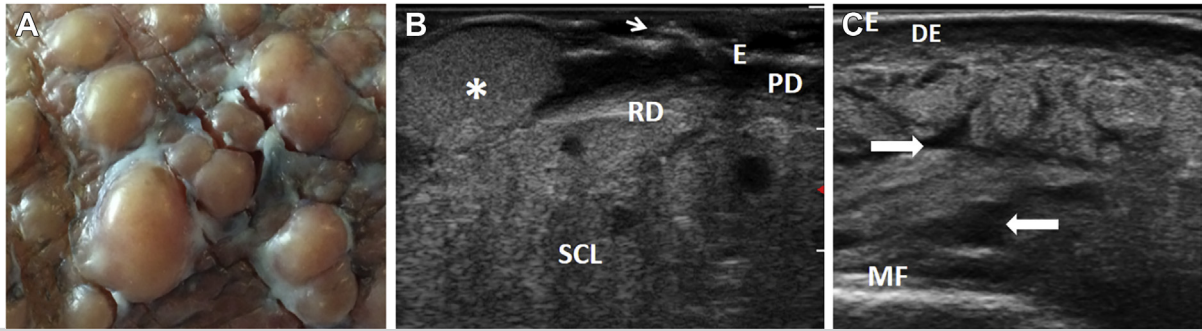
Patient G.L., 84 years old. A, The cobblestone-like appearance of verrucous hyperplasia of the skin (VHS). Note the thin skin fissures. B, The corresponding ultrasound appearance. The epidermis (*E*) is discontinuous (*arrow*). The papillary dermis (*PD*) is thickened and edematous. Reticular dermis (*RD*) proliferations (*) are the core of the verrucous-like projections. The subcutaneous layer (*SCL*) is hyperechogenic because of inflammatory infiltration. C, Ultrasound appearance of skin not affected with verrucous projections. Note the regular epidermal profile (*E*), marked dermal edema (*DE*), widened lymphatic clefts, and suprafascial fluid accumulation (*arrows*). *MF*, Muscular fascia.
